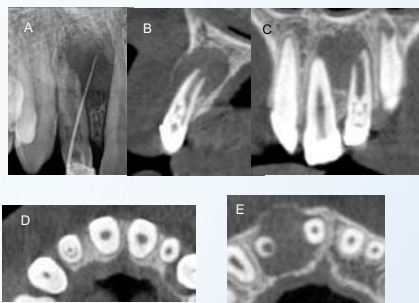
Radiographic images. (A) initial; (B) CBCT sagittal. (C) CBCT coronal. (D and E) CBCT axial.
